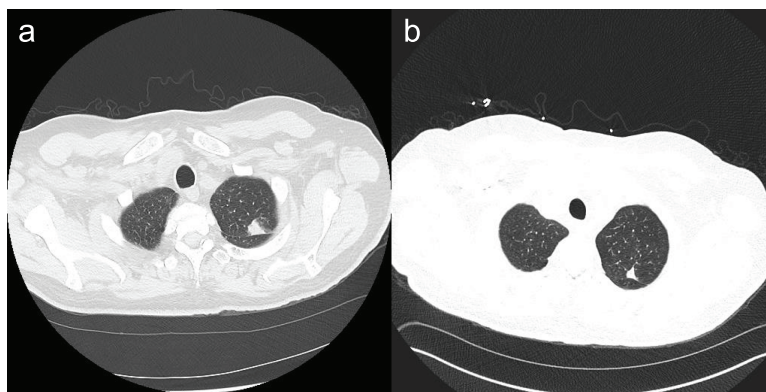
(a) CT of chest from outside the hospital showing the focal nodular area of consolidation within the left upper lobe posteriorly, measuring 1.6×1.1 cm and (b) CT of chest after both antibiotic and steroid treatment; left upper lobe posterior consolidative opacity adjacent to the fissure has decreased.
